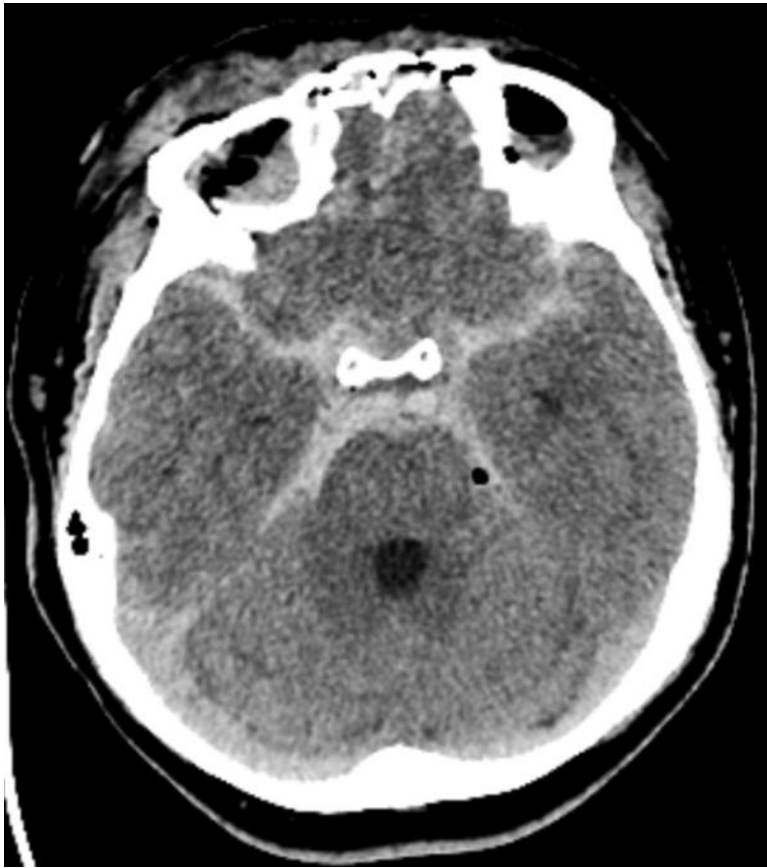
CT Brain on admission post trauma noted multiple intracranial haemorrhages with acute generalised subarachnoid bleeds, pneumocranium and multiple bones fractures.
